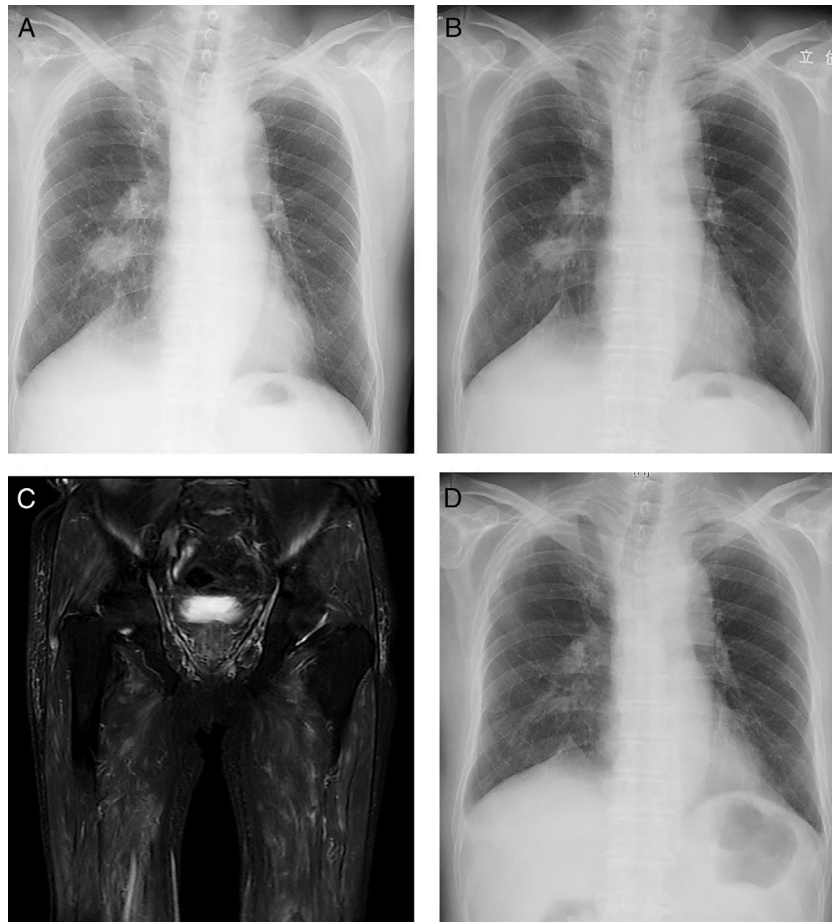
Chest X-ray images at a routine follow up (A) and 5 days after initial pembrolizumab administration (B). Short-tau inversion-recovery magnetic resonance image of the femur (C). Chest X-ray Image 2 months after initial pembrolizumab administration (D).
